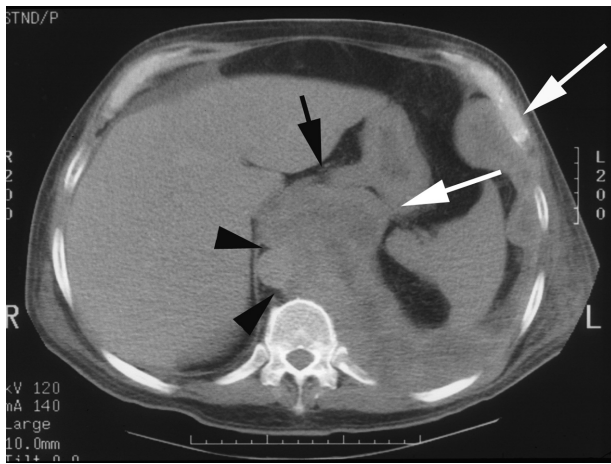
CT showing left MPM with extensive involvement of the diaphragm, including diaphragmatic crus and slips (*long arrows*). There is abutment and displacement of the descending thoracic aorta (*arrow heads*) and distal oesophagus (*short arrow*), highly suggestive (but not conclusive) of invasion.
